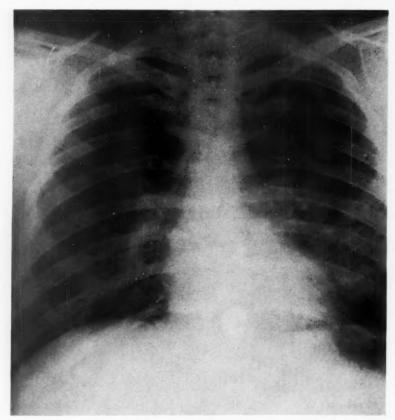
Chest x-ray, March 4, 1957, showing clearing of the infiltrates.
